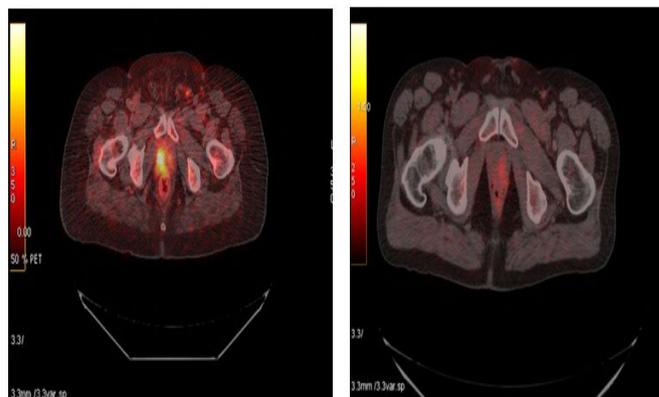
PET/CT image of a patient with prostate cancer before and after therapy. The left panel shows C-11 choline uptake in the prostate bed (scan acquired prior to therapy). After this scan patient underwent therapy. The right panel shows the PET/CT scan after patient completed therapy. No uptake of C-11 choline is noted in that region supporting the efficacy of C-11 choline to monitor prostate cancer therapy.
